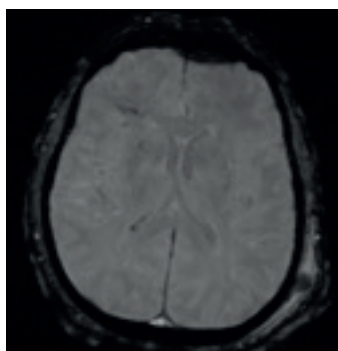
Cranial SWI MRI in the right frontobasal linear hemorrhagic in white matter signal losses grade 1 diffuse compatible with axonal injury hypointense area
